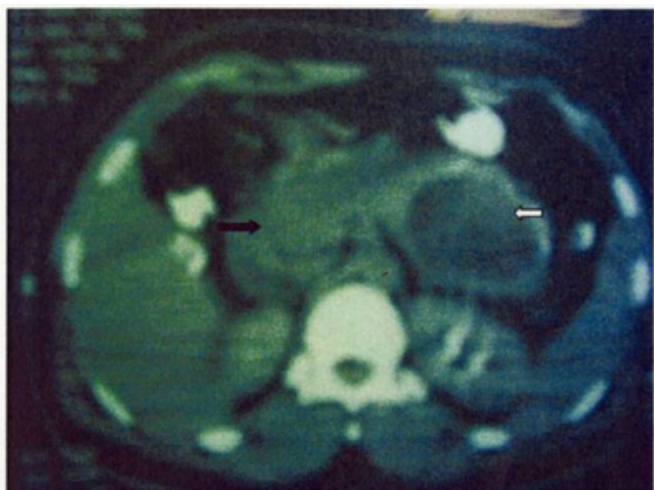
CT scan of the abdomen revealed cystic mass (white arrow) in the body and tail of the pancreas with other hypodense mass (black arrow) at the head of the pancreas.
